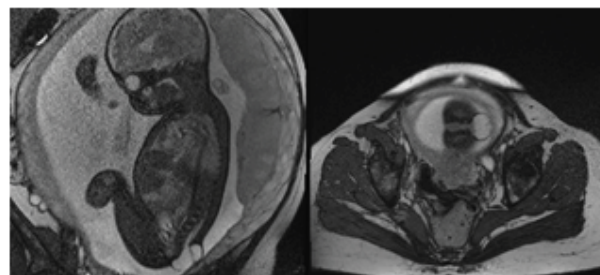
MRI demonstrated cystic structure at the dorsal aspect of lower part of spine that had protruded via dorsal sacral defects in lower segment, along with connection to spinal canal. Internal septa was seen (probably nerve roots). Skin seemed to be intact.
